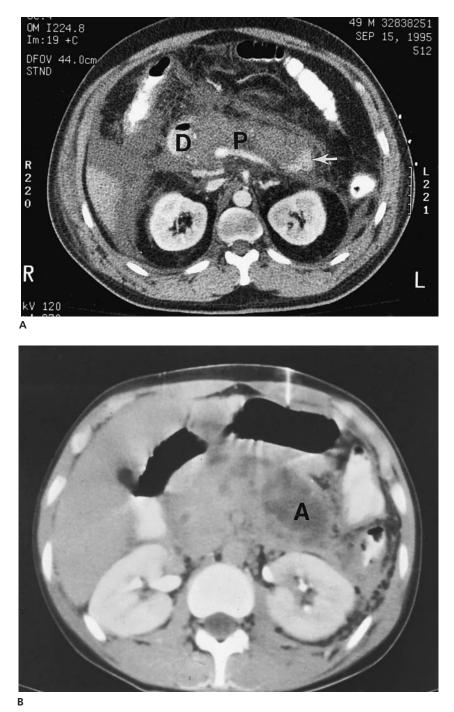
CE-CT scan demonstrates the presence of necrosis in severe pancreatitis. (A) A bolus of contrast is rapidly injected during CT scanning of the pancreas, enhancing vascularized pancreatic tissue (arrow) while areas of necrosis show as darker perfusion defects (letter P). The duodenum (letter D) marks the border with the necrotic head of the pancreas. (B) Even more extensive pancreatic necrosis is shown, with a large confluence of poorly perfused areas suggesting the presence of pancreatic abscess (letter A). (Courtesy of Henry I. Goldberg, MD.)
